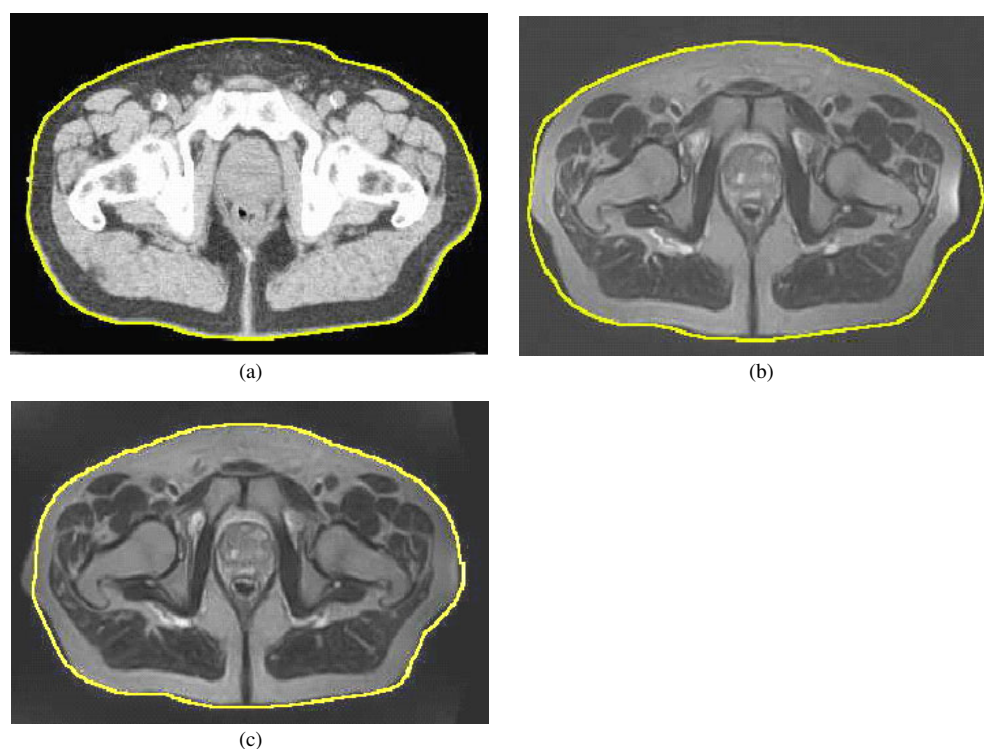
Comparison of CT and MR images for a prostate patient: (a) a distortion-free CT image, (b) an MR image before the GDC and (c) an MR image after the GDC.
